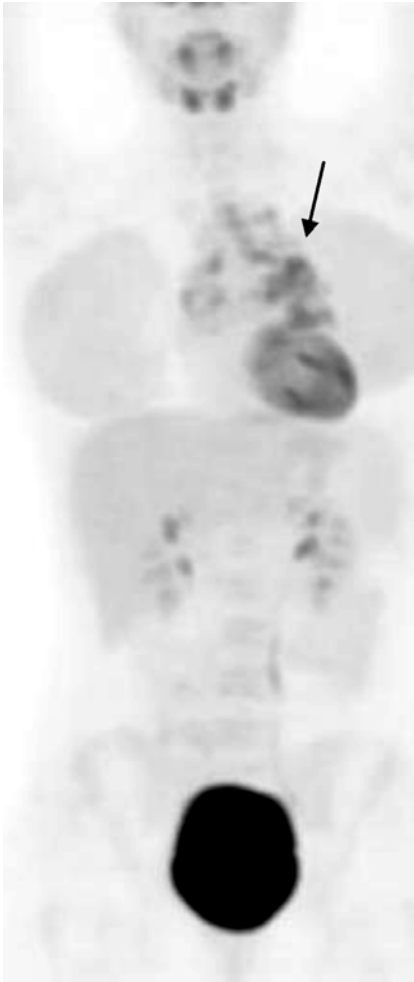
Interim PET/CT revealed persistently increased 18-FDG uptake (SUVmax 5) in the residual 11 cm mediastinal mass. The uptake moderately exceeded that of the liver, corresponding to a D5-PS score 4
